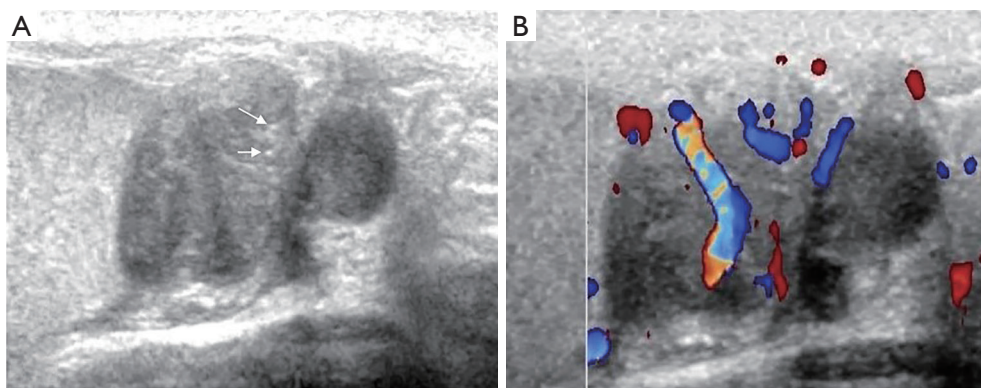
A 45-year-old male found a painless scrotal mass of one year duration by accident. (A) Grayscale of the left epididymis demonstrates a solid mass in epididymal tail signals, and calcification is observed (arrows). (B) CDFI shows abundant flow in the mass. CDFI, color Doppler flow imaging.
